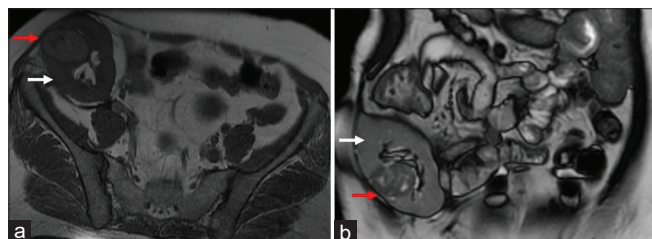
Magnetic resonance imaging abdomen. Axial (a) and coronal (b) images showing a completely endophytic tumor (red arrow) in the allograft kidney (white arrow) in the right iliac fossa
